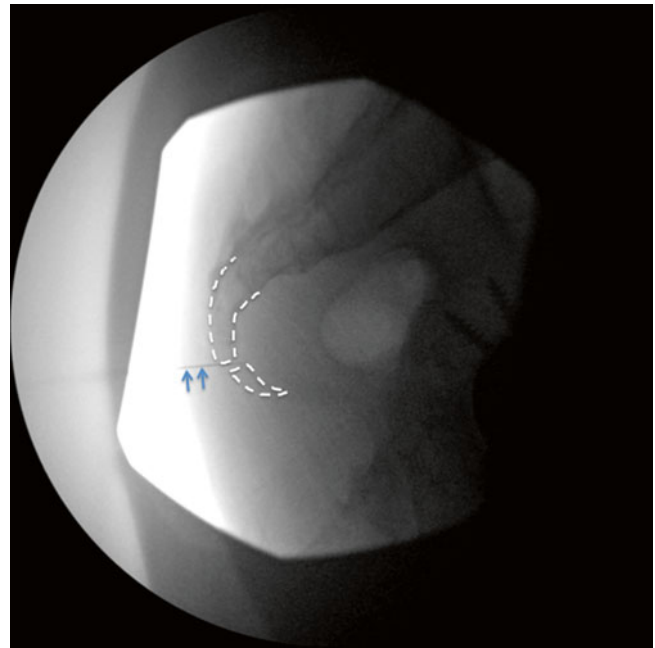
Lateral radiograph of sacrum and the sacrococcygeal junction. The sacrum and coccyx were outlined by *dotted* line, and the needle was indicated by line *arrows* (With permission from Philip Peng)
